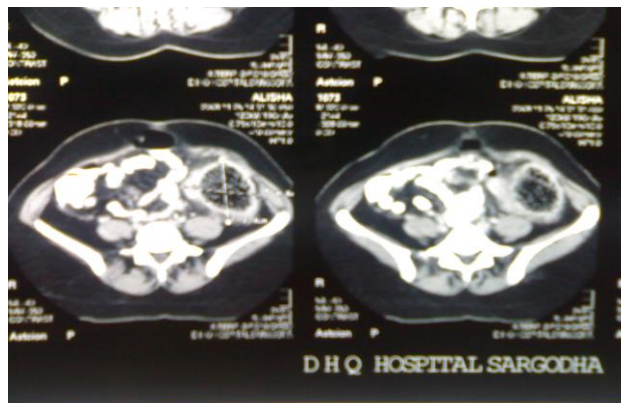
CT scan abdomen showing spongiform retained gauze piece.
